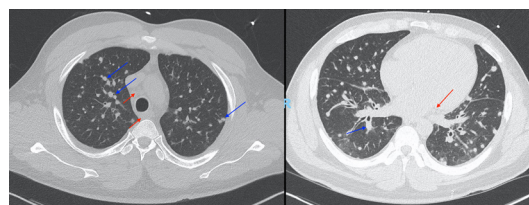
CT scan on initial presentation. Multiple bilateral pulmonary nodules (blue arrows) in a random distribution associated with mediastinal bilateral hilar lymphadenopathy (red arrows), favoured to represent either systemic granulomatous disease or metastatic disease with unknown primary.
